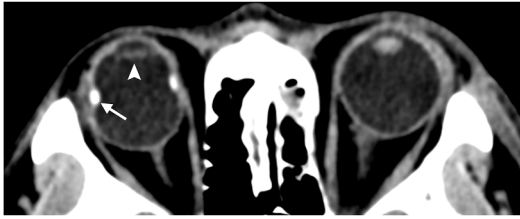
Axial CT orbits showing a right scleral buckle (arrow) and intraocular lens replacement (arrowhead).
